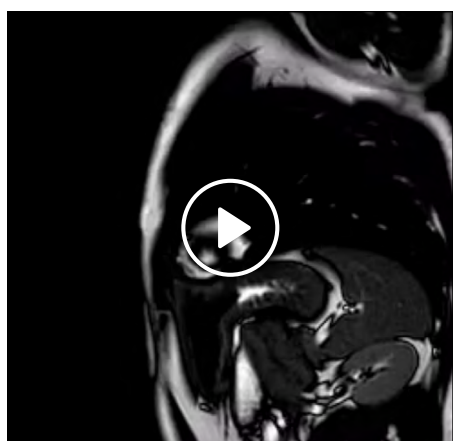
Cine cardiac magnetic resonance imaging depicts dynamic behavior of the multicystic lesion. (2a) Diastolic and (2b) systolic images from cine steady-state free precession-based left ventricular outflow tract; (2c) short-axis cine images at mid-cavity level and (2d) at basal to mid-cavity level, again confirming the multicystic structure in the basal to mid lateral/anterolateral wall of the left ventricle myocardium.
